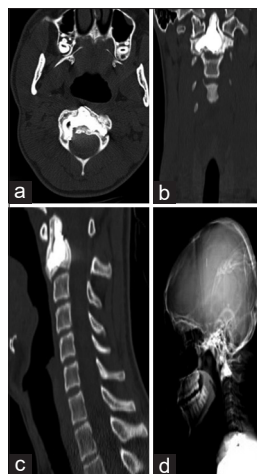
Follow-up CT scan examination of the cervical spine after 12 months. Areas of new bone formation were detectable around injected bone cement. Axial, coronal, sagittal, and Scott views from left to right, respectively. CT: Computerized tomography. axial (a), coronal (b), sagittal (c), scott view (d)
